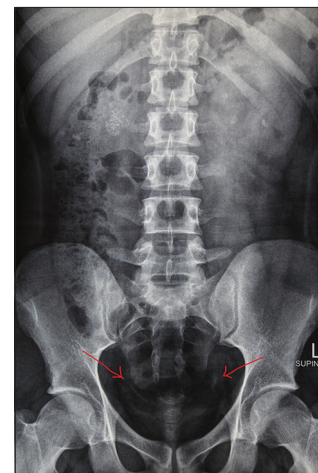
Plain X-ray of the abdomen (KUB) showing bilateral multiple small calculi in the lower pelvic part of both ureters (steinstrasse)
